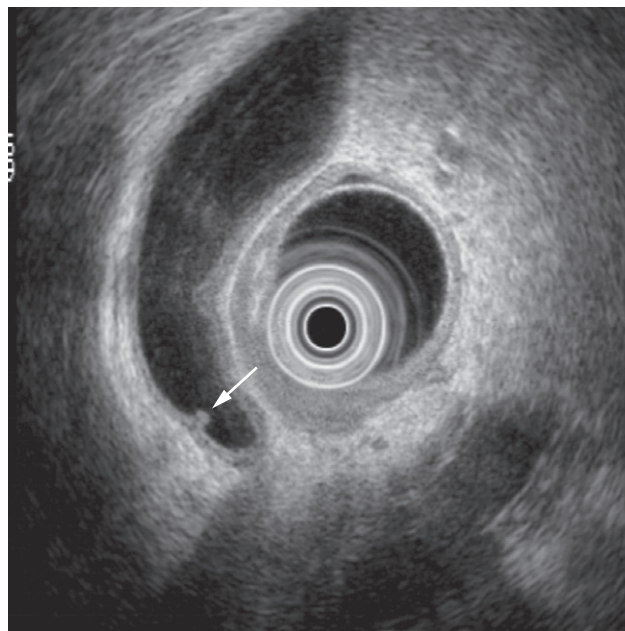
Endoscopic ultrasound showing a small polyp in the gall bladder with no acoustic shadow (arrow).
